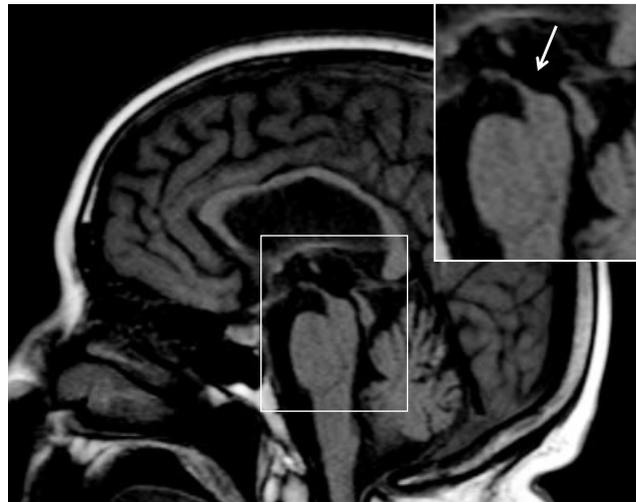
MRI showing convex aspect of the midbrain, indicating atrophy (arrow) typically observed in progressive supranuclear palsy (the normal midbrain aspect is concave).
